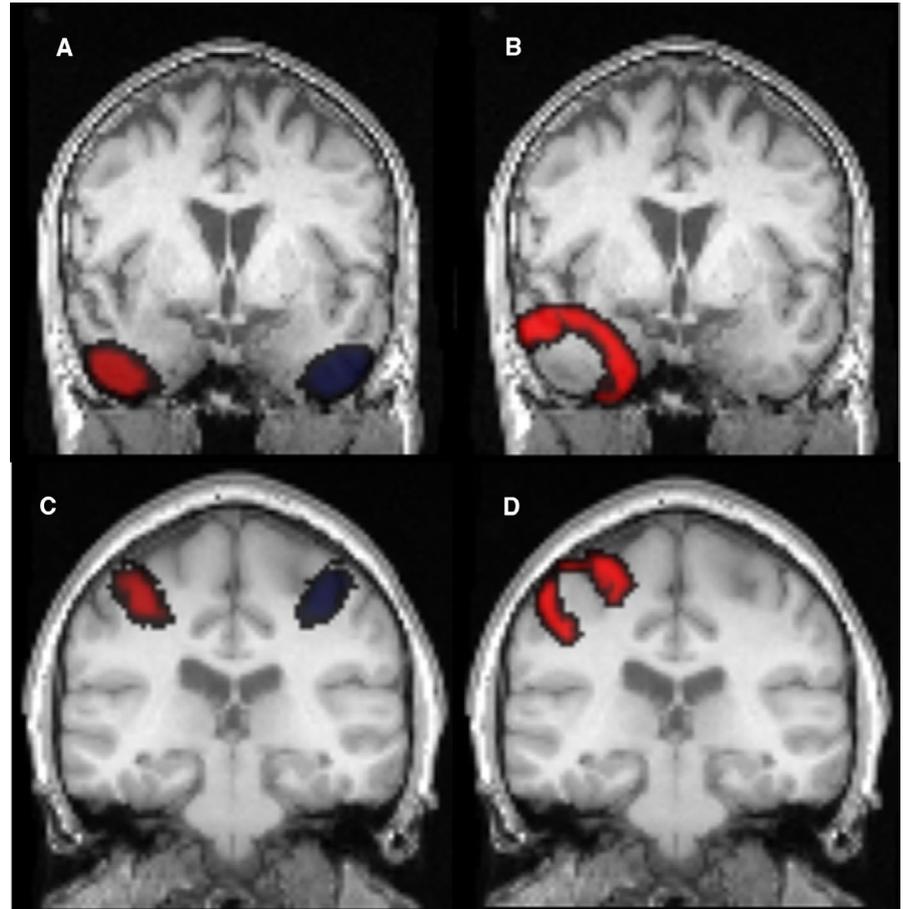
MRI of the epilepsy lesions and region-of-interest (ROI) placement. Images are displayed in neurological convention (subject's left is displayed on image left). Patient 1: ROI of the hamartoma (left inferior temporal gyrus) displayed in red and contralateral ROI in blue (A), with surrounding ROI seen in red (B). Patient 2: ROI of the presumed FCD (left posterior central gyrus) displayed in red and contralateral ROI in blue (C), with surrounding ROI in red (D)
